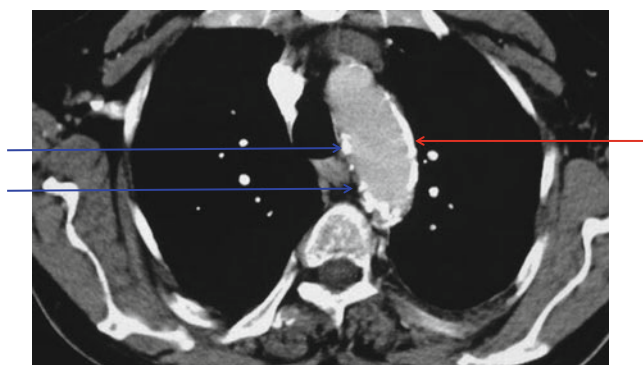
CT scan of the thorax at the level of the aortic arch, showing a large plate-like calcified area (*red arrow*) and some areas with more patchy distribution of calcified regions (*blue arrows*) (Courtesy of professor David Goldsmith)
